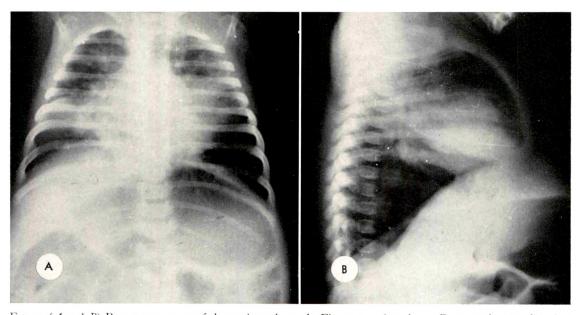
(A and B) Roentgenograms of the patient shown in Figure 2, 4 days later. Pneumonic consolidation has appeared in both lungs. Emphysema is still a very prominent feature. The child succumbed 4 days after these roentgenograms were made.
